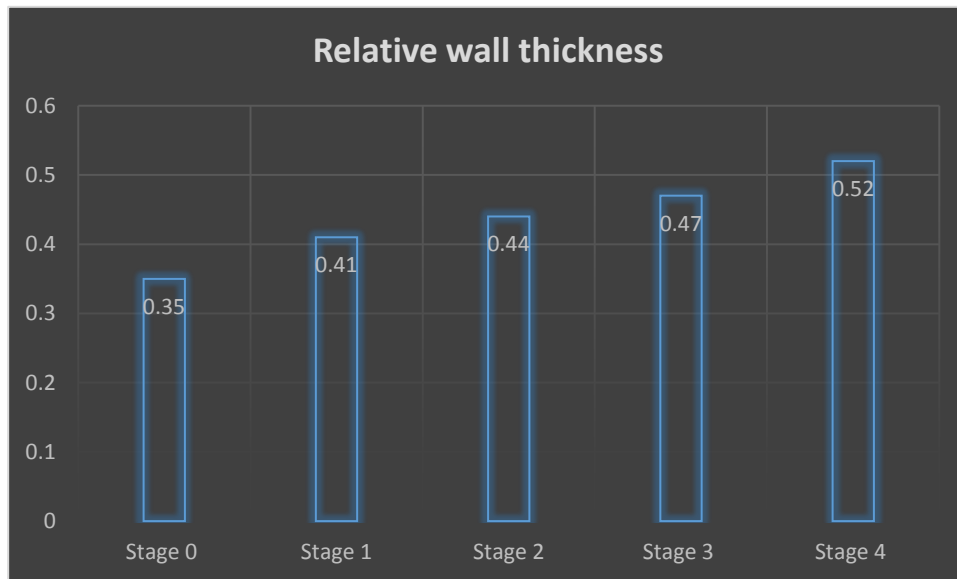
Comparison of Relative wall thickness in Echocardiographic Findings between Hypertensive Retinopathy (HR) Stages
